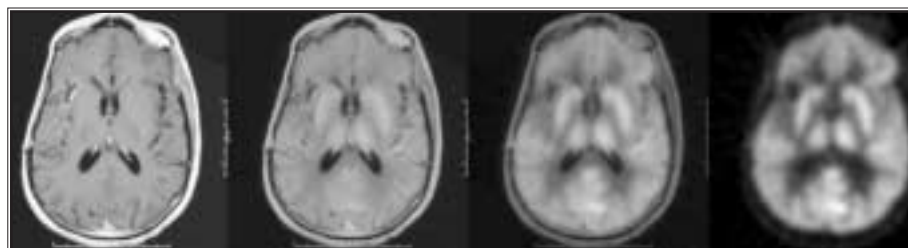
53-year-old woman status postresection of right frontoparietal anaplastic astrocytoma six months earlier. Patient is clinically stable. T1 gadolinium-enhanced MR image reveals mild enhancement. FDG-PET scan reveals no accumulation in area of enhancement, which represents post-therapeutic change.
